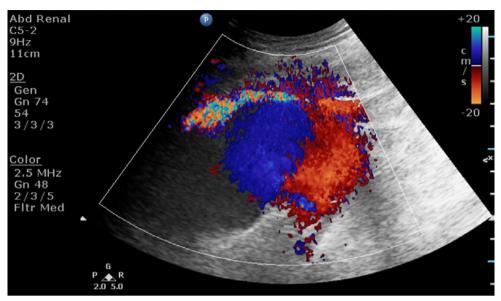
Color Doppler ultrasound transverse scan of the left upper thigh depicts the high-velocity jet of blood entering the pseudoaneurysm.
